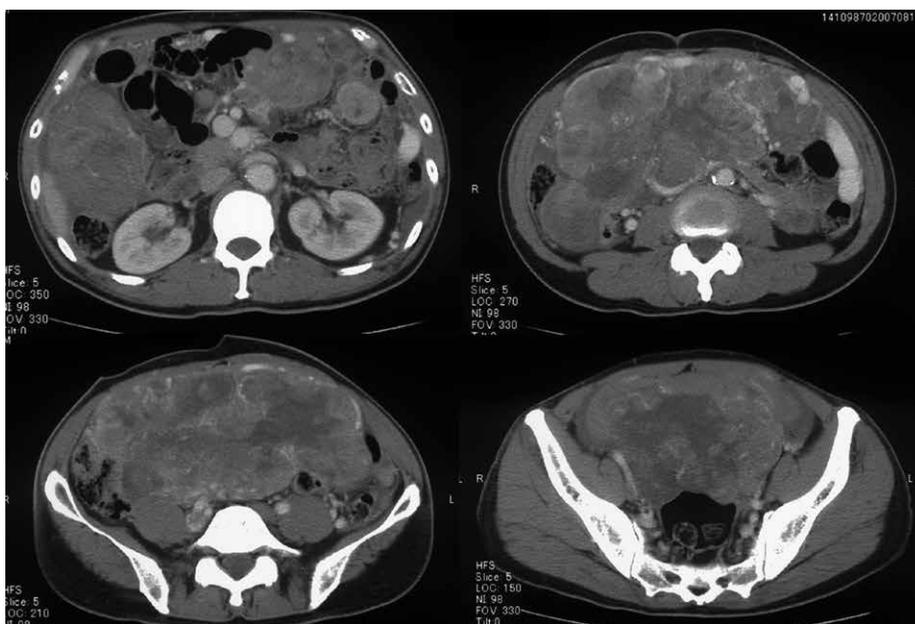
Abdominal CT images revealed a giant tumor 210×120×200 mm in size in the abdominal cavity.
